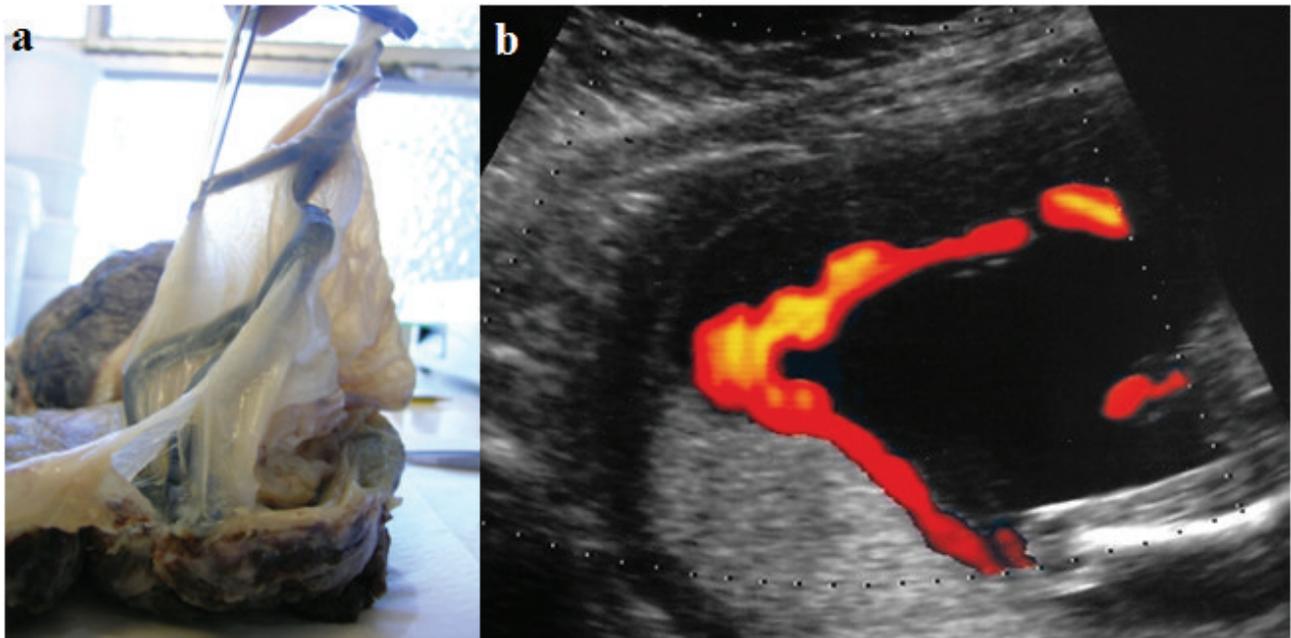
a) Velamentous cord insertion *in vivo* (courtesy of Otilia Brandão MD); b) Velamentous cord insertion in ultrasonography (courtesy of Nuno Montenegro PhD MD).
